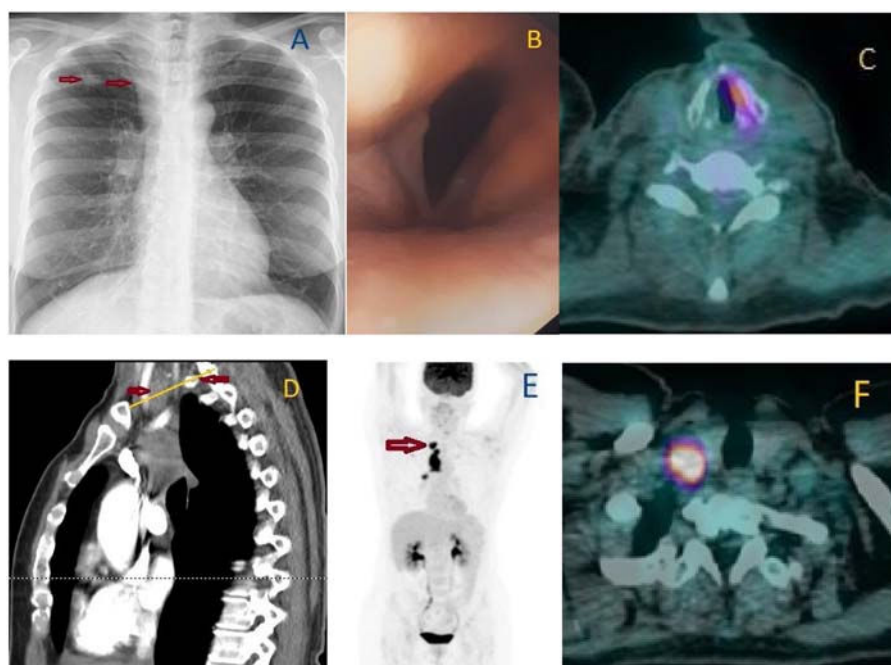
(A) Chest X-ray. Right apical solitary nodule and thickening of the right paratracheal stripe (arrows). (B) Endoscopic view of the larynx reveals RVCP. (C) CT-PET at the larynx. No uptake in the right vocal cord is compensated by hypermetabolism in the left one. (D) Chest CT, sagittal view. A lower neck adenopathy (left arrow) lies just above the level of the first rib's (right arrow) trajectory (line). Therefore, it belongs to the 1R nodal station.¹ (E) PET scan. Increased uptake of the radiotracer noted at 1R (arrow), 2R, 4R and 10R nodal stations. The lung nodule was also hypermetabolic (not shown). (F) CT-PET reveals hyperactivity in the right juxta thyroid adenopathy (1R).
